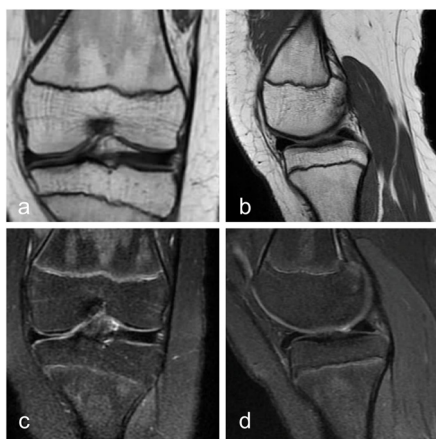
Postoperative MRI of the left knee, 24 months after the fixation of the M.F.C, OCD lesion with Chondral Darts. Complete healing of the OCD lesion.
